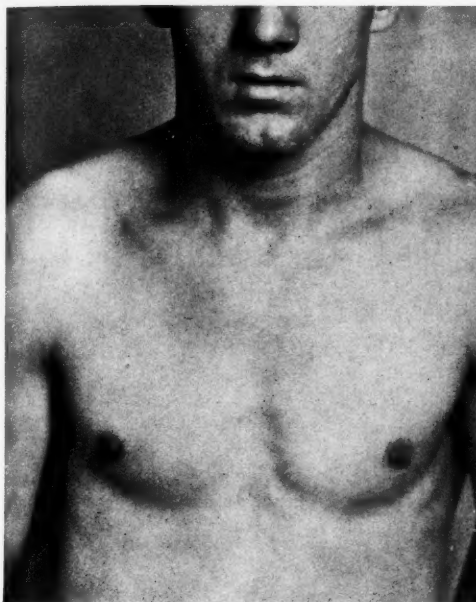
Case 1. Anterior view of the patient shown in Fig. 1, eight and one-half years after the last administration of irradiation by deep X-rays, showing an absence of gynecomastia.
